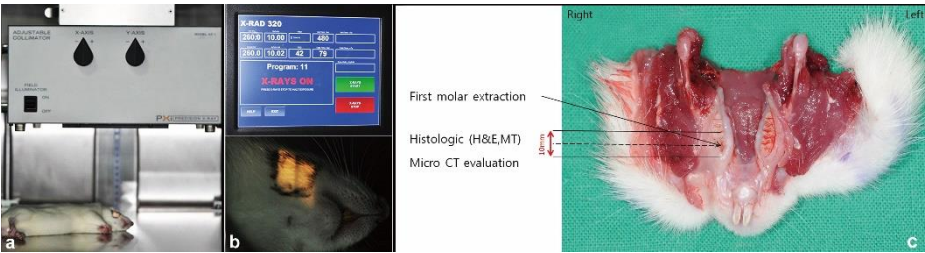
Radiation delivery procedures, (a) 2x1-cm skin marking on the left mandible; (b) X-RAD 320 Irradiator® (Precision X-ray Inc., North Branford, USA) settings; (c) beam focused on the planned surface for testing
